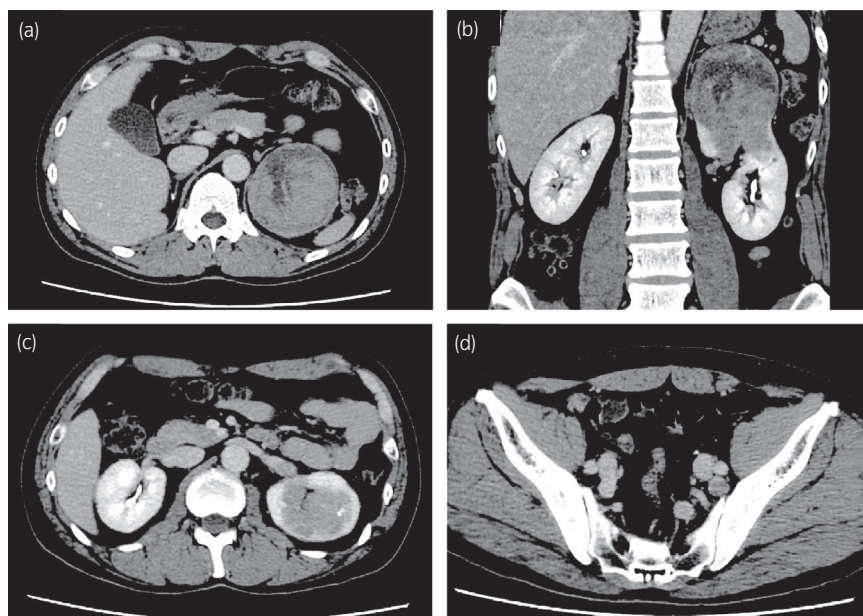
CT imaging findings before nephrectomy. (a) Abdominal enhanced CT showed the size of the left renal tumor as 74 mm on axial imaging and (b) as 93 mm on coronal imaging. (c) Abdominal enhanced CT axial image of the left renal tumor and tumor thrombus in the left renal vein. (d) Abdominal enhanced CT of the 16-mm lymph node at the left external iliac area.
